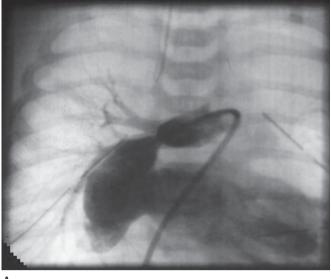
Pulmonary arteriovenous malformation. The chest radiograph (*left*) in a patient with cyanosis, finger clubbing, and a bruit heard in the right chest revealed a rounded parenchymal shadow in the right lung, which was confirmed on pulmonary arteriography (*right*) to represent a large pulmonary arteriovenous malformation.
